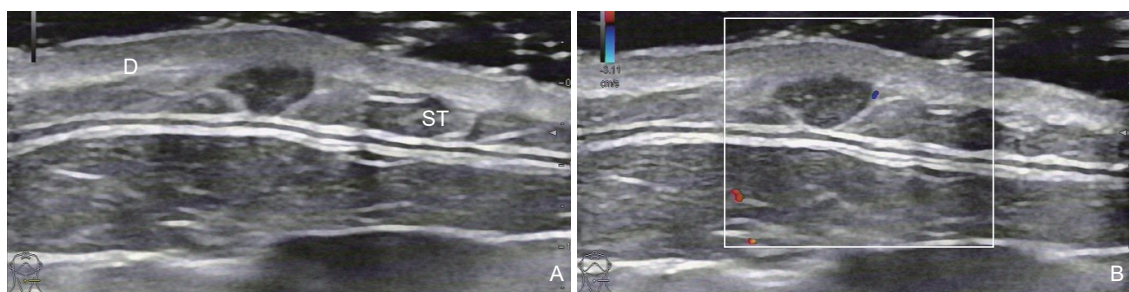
A epidermoid cyst bellowed dermis (D) and in subcutaneous fat layer (ST). (A) Ultrasound scan found a 6×3mm irregular-shaped hypoechoic cystic lesion in subcutaneous fat layer; (B) Color Doppler showed no blood flow signals in the lesion.
